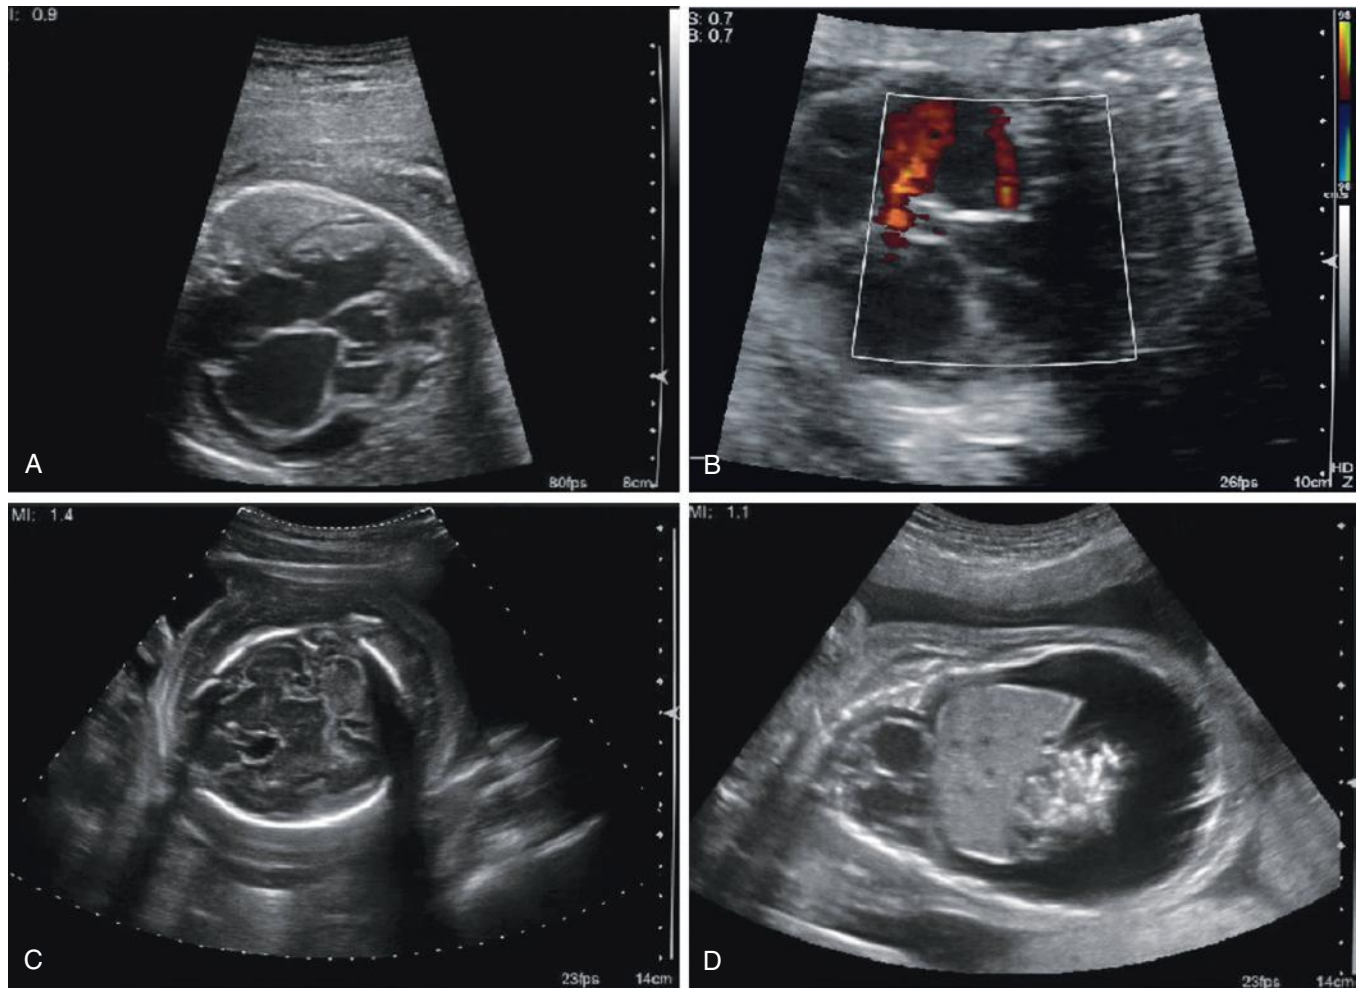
Fetus with primary cardiomyopathy. A, The four-chamber view demonstrates marked hypertrabeculation of both ventricles with severe enlargement of the atria and a pericardial effusion. B, Color Doppler demonstrates moderate mitral and severe tricuspid regurgitation. C and D, There is fetal hydrops, as evidenced by scalp edema, body wall edema, and ascites.
